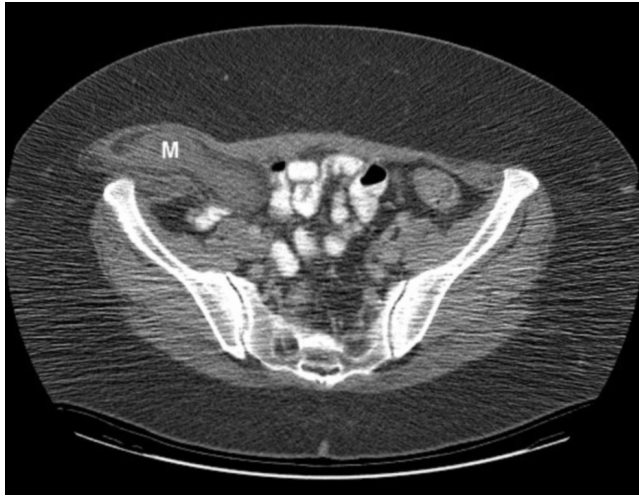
Initial CT examination, demonstrating a mass (M) posterior to the right abdominal wall.
